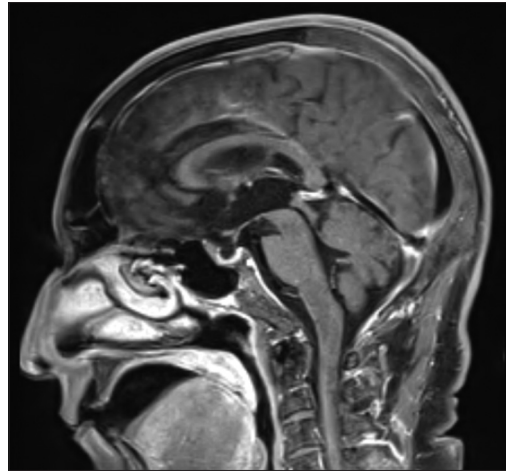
Sagittal contrast enhanced magnetic resonance imaging section at the level of aqueduct in midbrain
